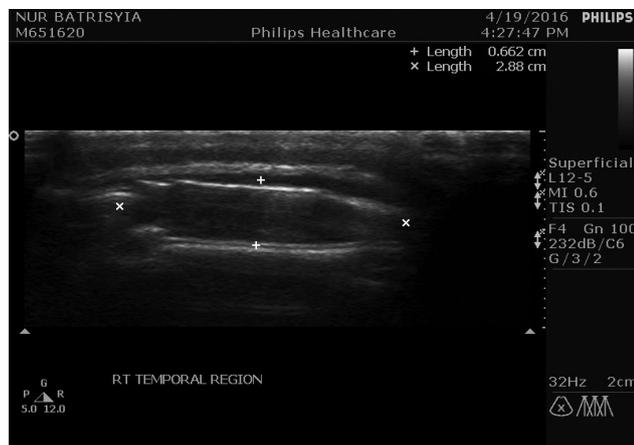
Shows an ultrasonography of Right Temporal Region. Scalp sonography with the probe positioned superficial to the recipient site of right cochlear implant exhibited an ovoid anechoic lesion measuring 2.8 cm. There was no internal echogenicity detected to suggest debris or septation. Doppler interrogation revealed no significant signal uptake.
